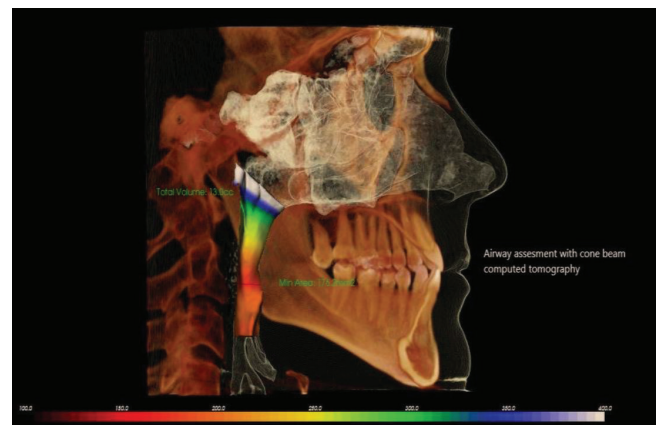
Airway analysis using CBCT
